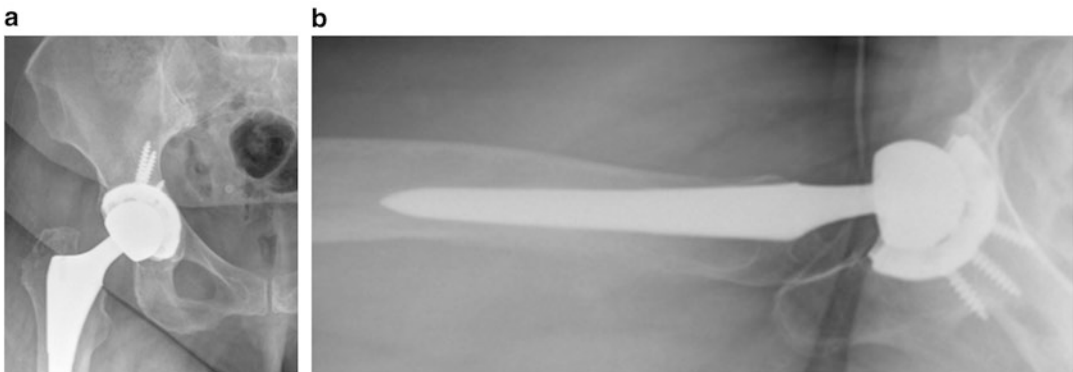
The above patient underwent revision of the acetabular component with increased anteversion as noted on the anteroposterior hip (a) and cross-table lateral (b) radiographs. Patient had groin pain resolution without postoperative complication
